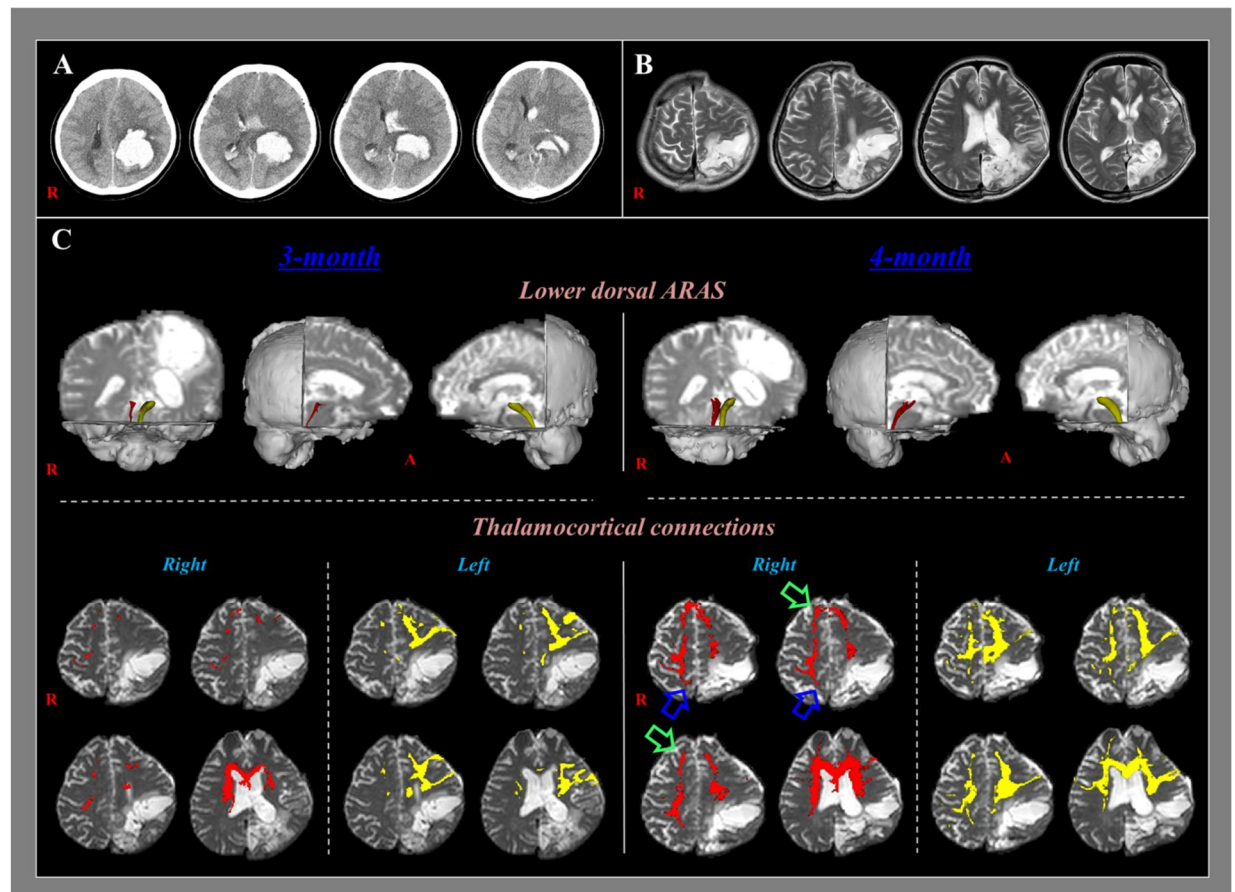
(A) Brain computed tomography images at onset show hematoma in the left parietal lobe and subfalcine herniation. (B) Brain magnetic resonance images at three months after onset reveal leukomalactic lesions in the left parieto-occipital lobes. (C) Results of diffusion tensor tractography (DTT). On 4-month post-onset DTT, thickening of the right lower dorsal ARAS is observed compared with that on 3-month DTT. Decreased neural connections to the right frontoparietal lobes on 3-month DTT are shown to be increased on 4-month DTT, especially in the right medial prefrontal cortex (green arrows) and precuneus (blue arrows).
